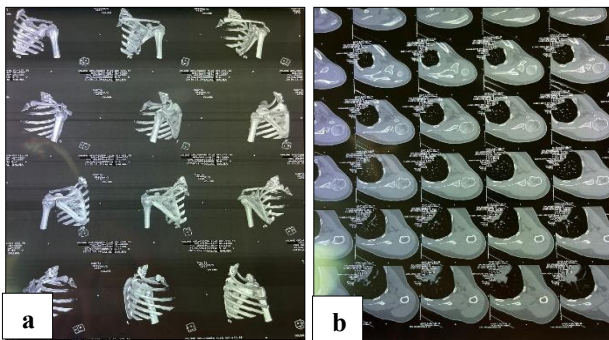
(a and b): CT images.
